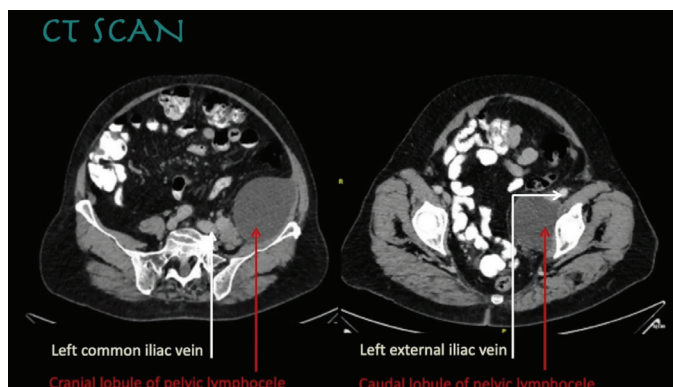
Computed tomography scan showing two images suggestive of the presence of pelvic lymphocele
